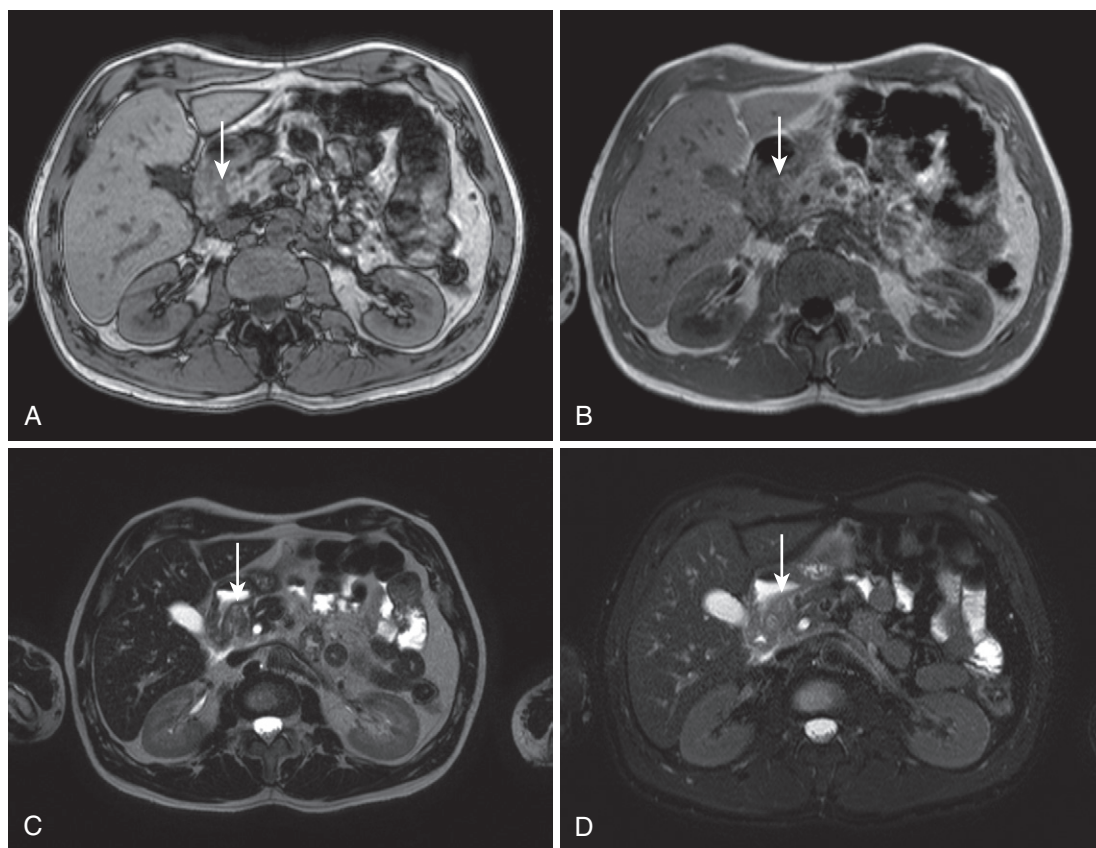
Groove pancreatitis. Out-of-phase (A) and in-phase (B) T1-weighted gradient recalled-echo images demonstrate decreased T1-weighted signal intensity in the pancreaticoduodenal groove with corresponding increased signal intensity on T2-weighted (C) and fat-suppressed T2-weighted (D) images (arrows) as well as retroperitoneal edema in a patient with groove pancreatitis.
